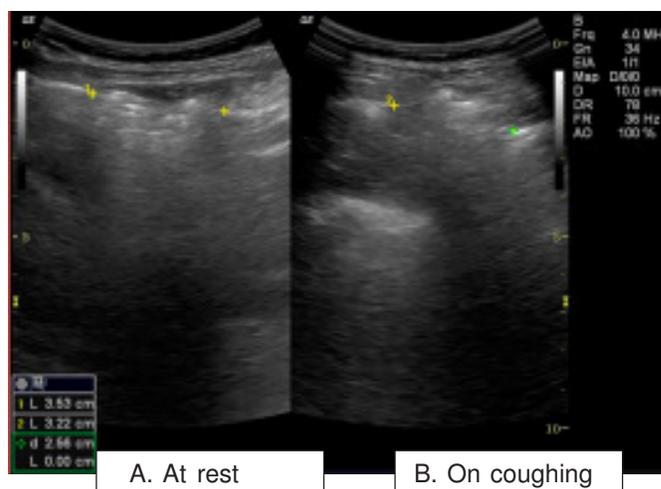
Ultrasound Abdomen
